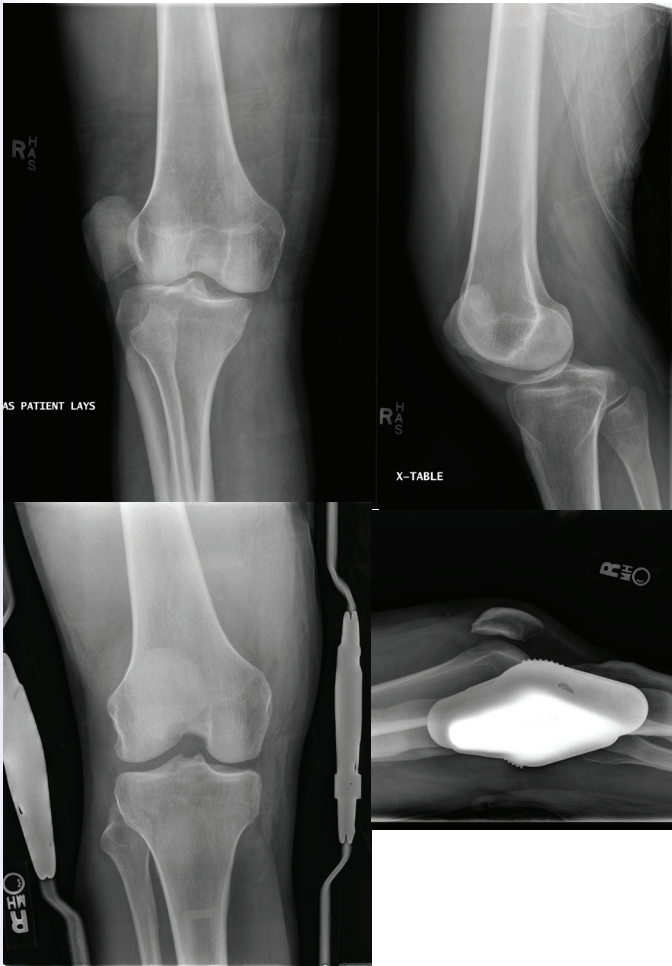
Unstable KDIV which was easily closed reduced. While admitted noted increasing knee pain and radiographs revealed subluxation in the brace. Ex-fix versus operative repair considered.
